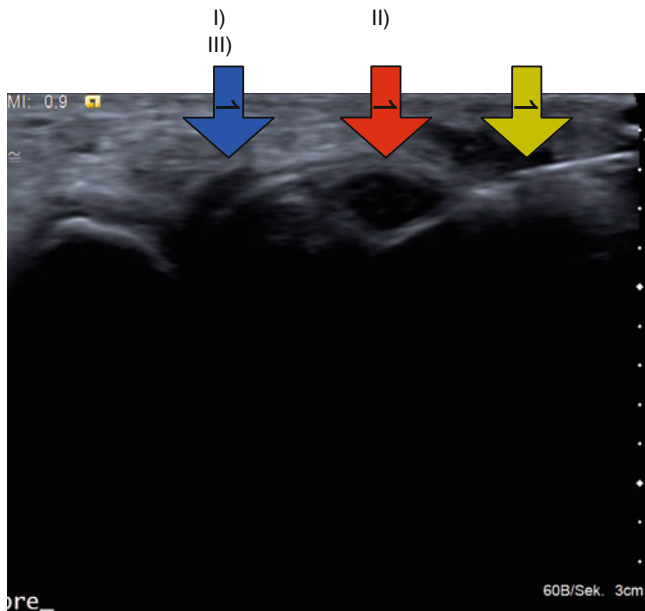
Median nerve, local intervention: This image shows a local steroid application in a case of CTS recorded by ultrasound. *I* Retinaculum flexorum (blue arrow), *II* median nerve (red arrow), *III* intervention needle next to the median nerve (yellow arrow)
